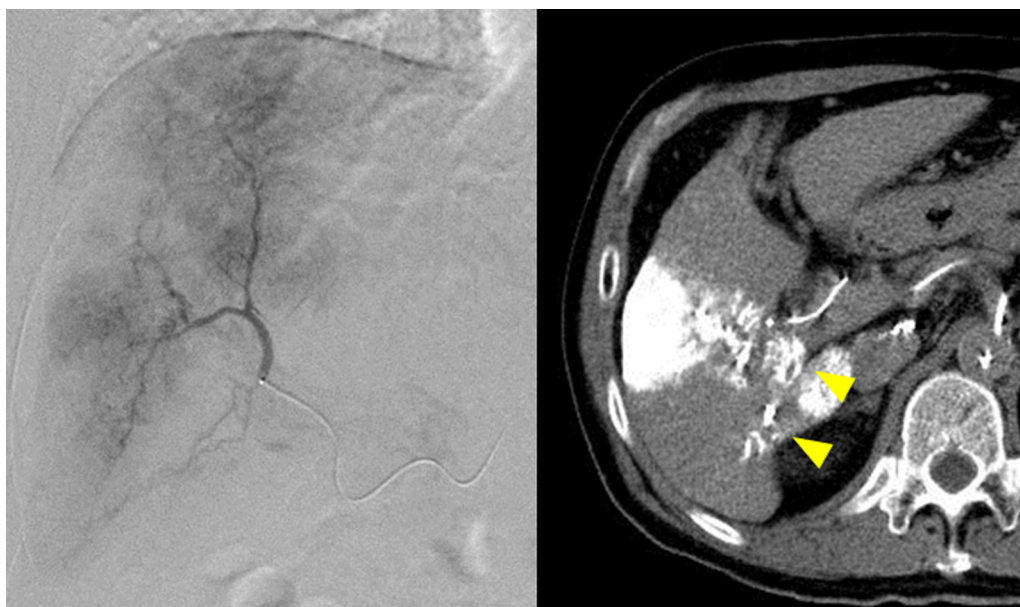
The first TAI treatment was done through an injection in the anterior sectional branch of the right hepatic artery (A5/A8). At the same time, we confirmed accumulation of iodized oil in the main lesion and portal vein tumor thrombus with plain CT imaging (arrowhead).
